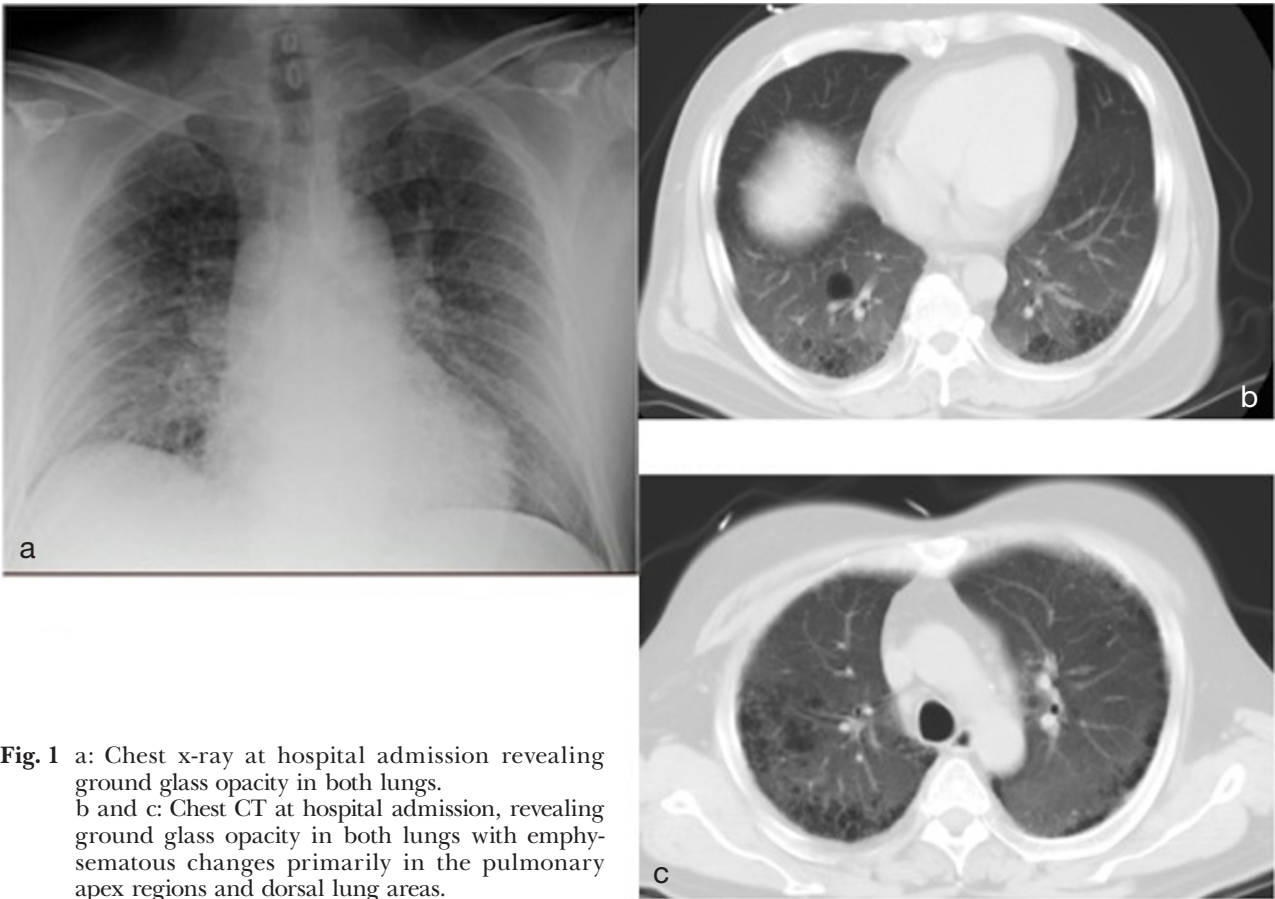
a: Chest x-ray at hospital admission revealing ground glass opacity in both lungs.
